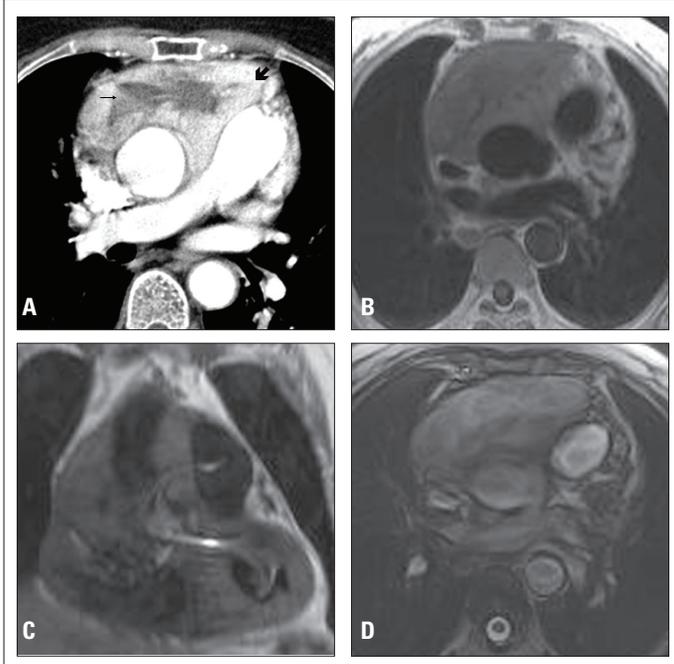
A) CT image of strongly-enhancing mass (thick arrow), with a necrotic central portion (thin arrow), encasing pulmonary artery and aorta. T1-weighted axial (B) and coronal (C) MR images of intrapericardial, heterogeneous mass of low signal intensity at aorticopulmonary region (D) T2-weighted axial MR image of the lesion with higher signal intensity than muscle and less signal intensity than surrounding fat tissue
